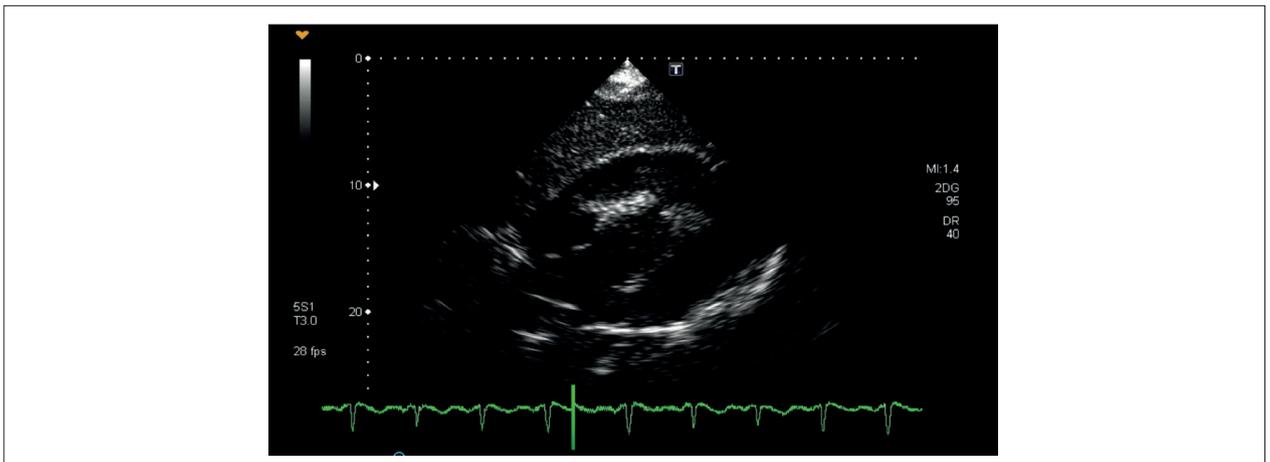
Transsthoracic echocardiogram (4-chamber apical view) showing massive pericardial effusion with increased density, associated with the lateral wall of the left ventricle. Right ventricle; LV: left ventricle; AO: aorta; PE: pericardial effusion; RA: right atrium; LA: left atrium.
